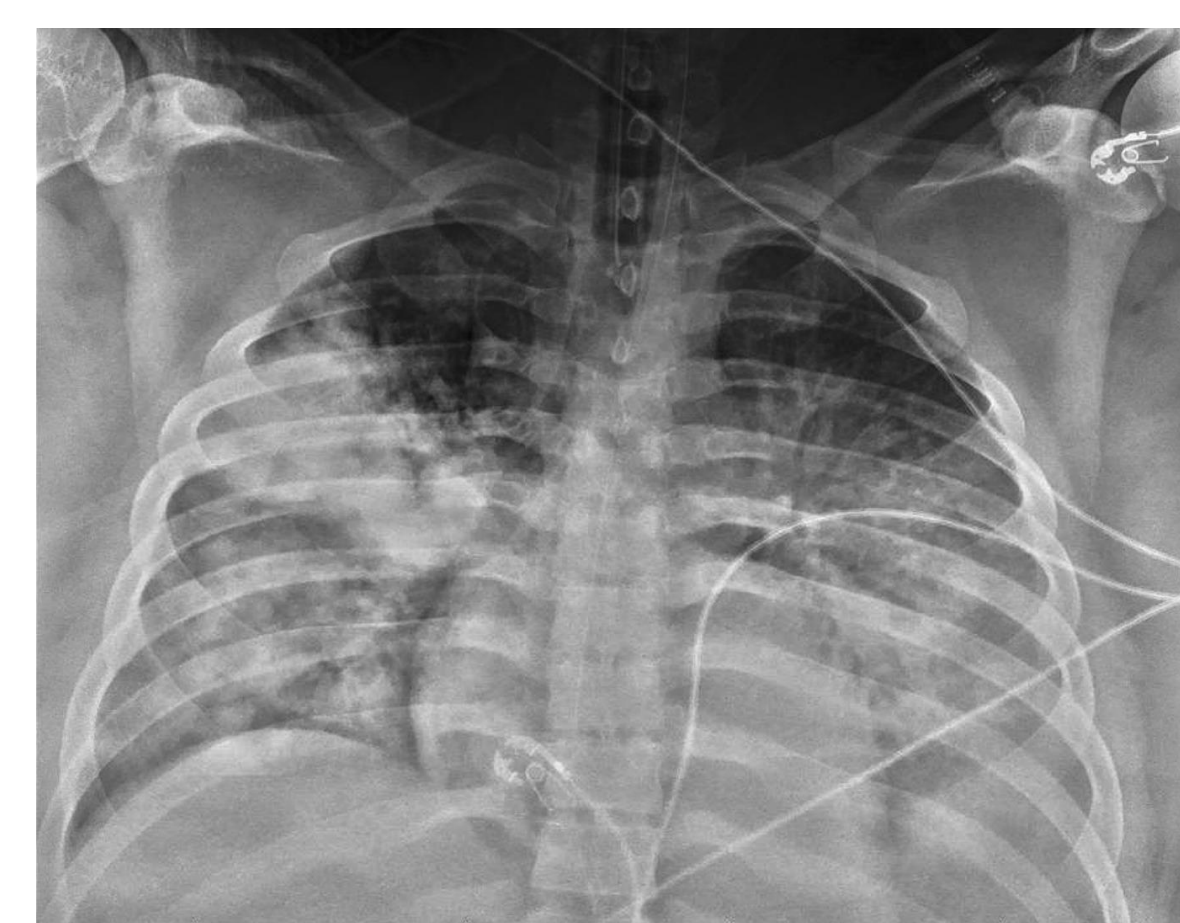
Radiographic imaging of a patient with laboratory confirmed blastomycosis and clinically diagnosed ARDS⁵
